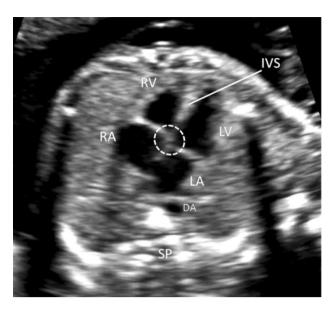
Transverse axial sonogram of thorax showing 4 chamber fetal heart at 20 weeks scan. *SP* spine, *DA* descending aorta; *RA* right atrium, *RV* right ventricle, *LA* left atrium, *LV* left ventricle, *IVS* interventricular septum, Dotted circle- crux of the heart
